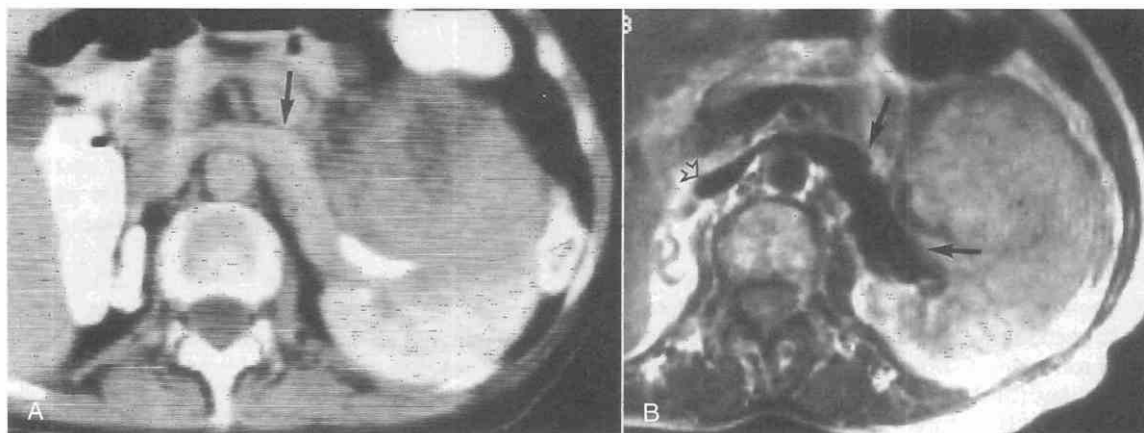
Left renal cell carcinoma with renal vein enlargement (arrow) on contrast-enhanced CT scan (*A*). The right kidney is atrophic. On MRI (*B*) (spin-echo, TR = 2100 msec, TE = 30 msec), the left renal vein (arrows) is enlarged but shows a normal signal void, indicating that venous enlargement is probably due to increased blood flow rather than tumor extension. The inferior vena cava (open arrow) is also normal.
